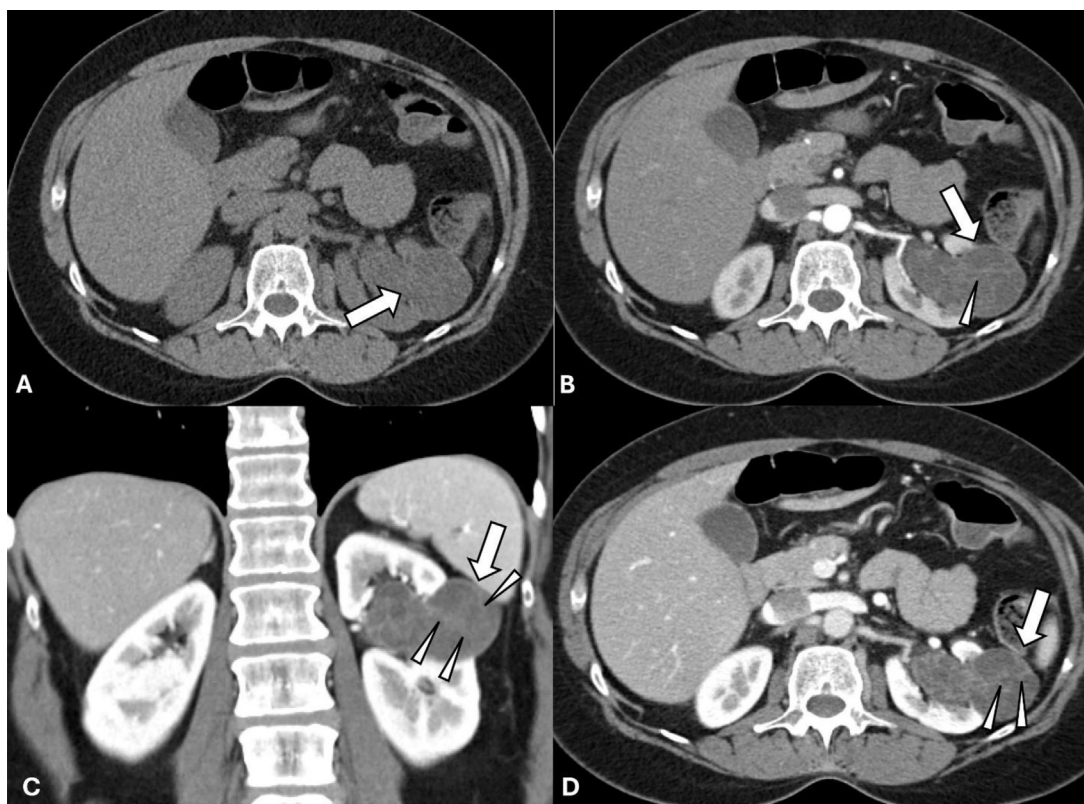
51-year-old found with incidental left cystic mass. Axial unenhanced (A), axial (B) and coronal (C) arterial phase contrast-enhanced, and axial nephrographic phase contrast-enhanced (D) CT demonstrate a circumscribed, mildly lobulated, partially exophytic, multiseptated left interpolar cystic structure (arrows). There is associated mild enhancement of multiple internal septa (arrowheads) without calcifications or discrete mural nodule.
